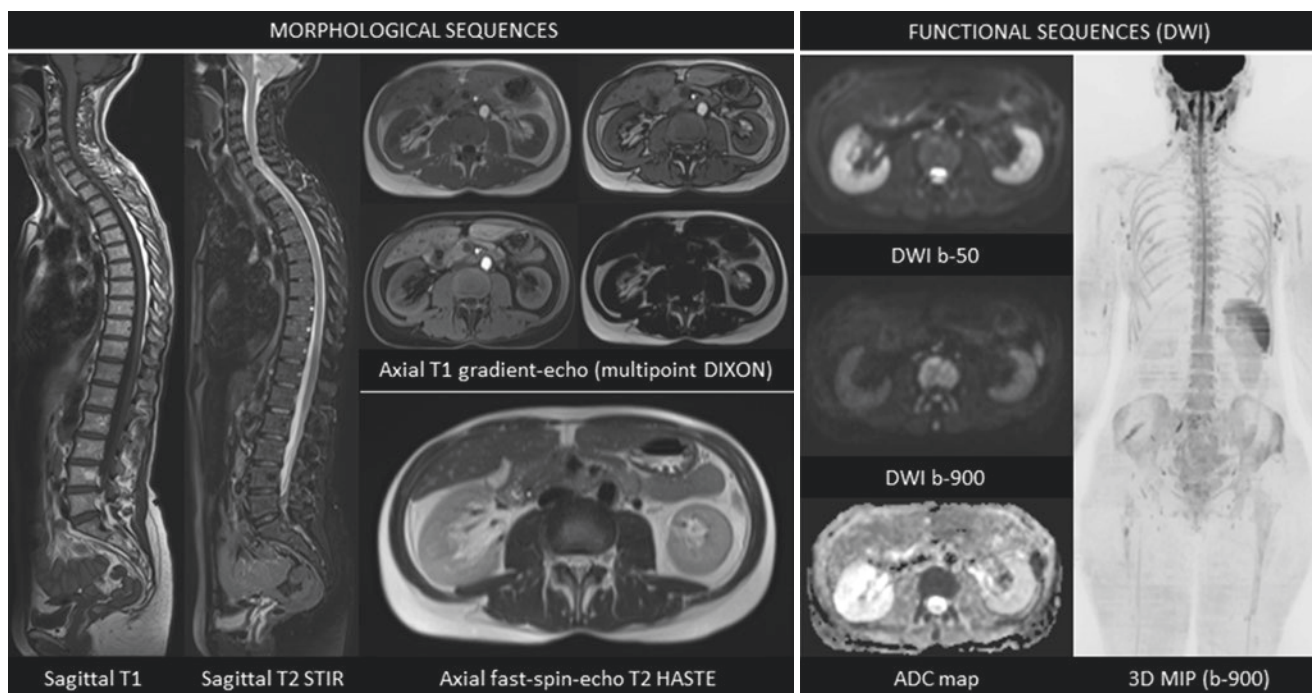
Diffusion whole-body MRI consisting of sagittal T1-weighted and T2-weighted sequences on the whole spine, axial T1-weighted (multipoint DIXON), T2-weighted and diffusion-weighted images from head to mid-thigh, performed on a 1.5 T scanner (Magnetom Avanto, Siemens Healthcare Sector, Erlangen, Germany). Anatomy-specific phased-array surface coils are used for all body
